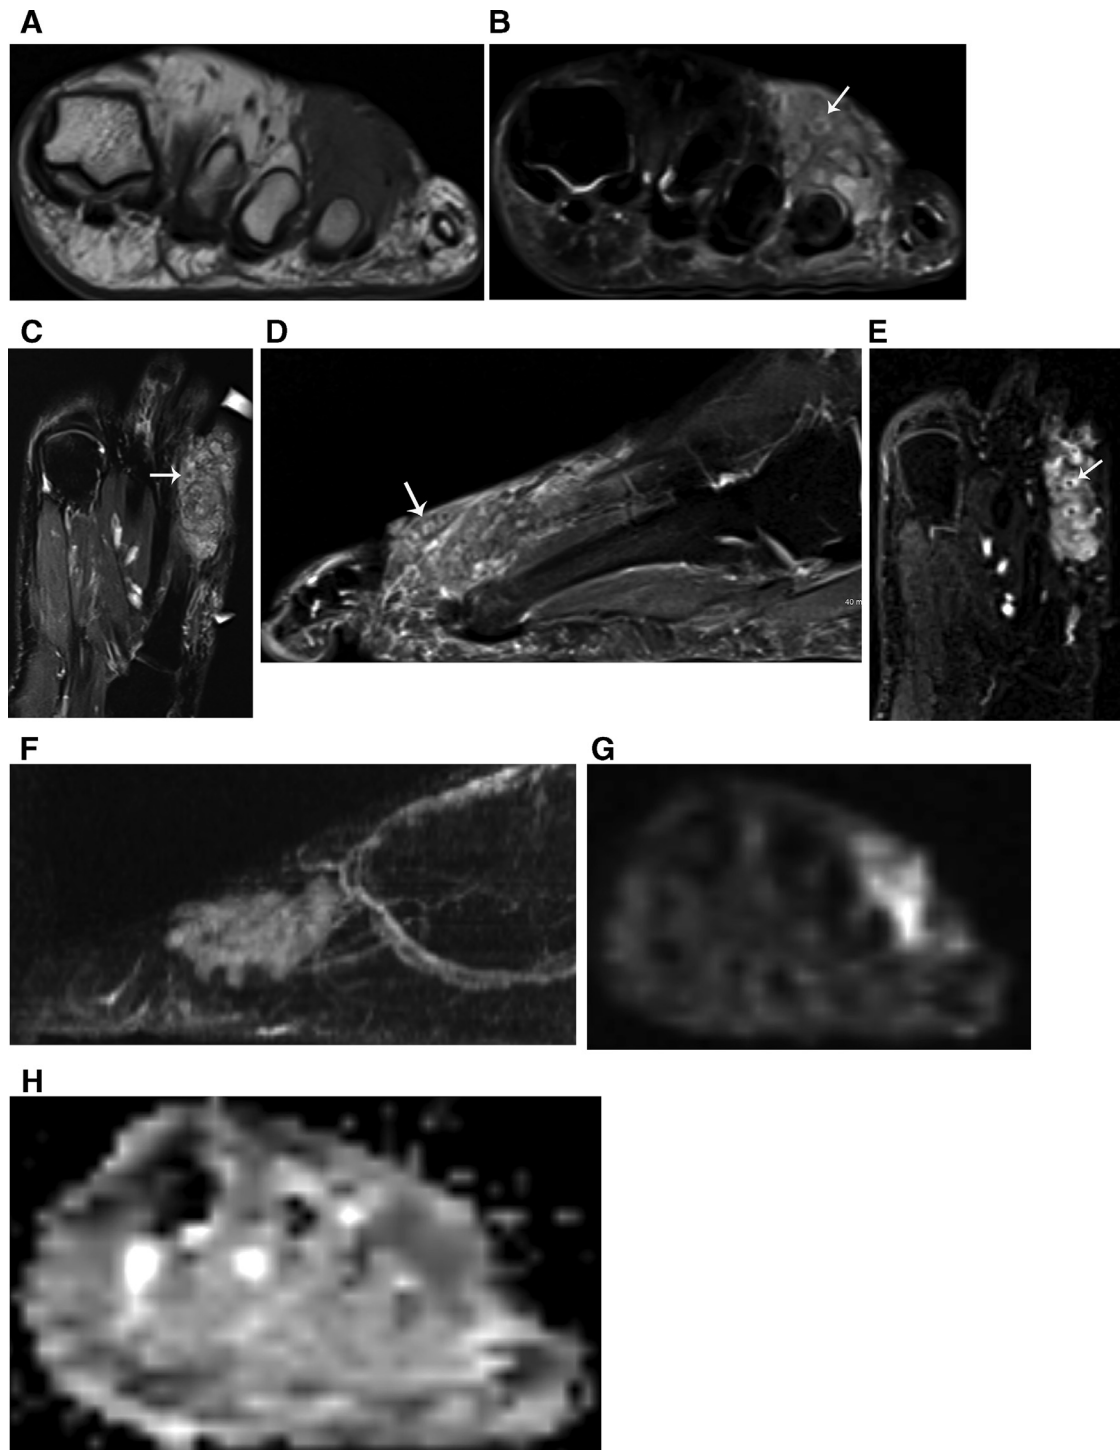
(a–h) MR imaging obtained on current encounter shows a soft tissue lesion at the area of prior surgical resection dorsal to the fourth metatarsal head. The lesion is isointense to muscle on T1-weighted image (a) insinuating into the third and fourth web-spaces. The lesion appears larger compared to the prior MR imaging. Axial (b) and sagittal (c) T2-weighted fat-saturated images and coronal STIR image (d) demonstrate a conglomerate of rounded bright signal intensity foci with central low signal intensity (dot-in-circle sign). This sign is even more conspicuous on postcontrast coronal T1-weighted fat-saturated VIBE subtraction image (e). TWIST MR angiography (f) shows an area of hypervascularity corresponding to soft tissue lesion. The lesion demonstrates mild diffusion restriction with bright signal intensity on b800 diffusion image (g) and ADC value of $0.95 \times 10^{-3} \text{ mm}^2/\text{s}$ (h). ADC, apparent diffusion coefficient; TWIST, time-resolved angiography with stochastic trajectories.
